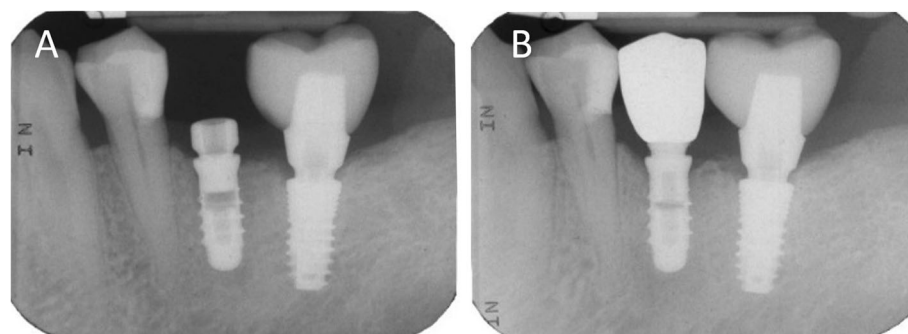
Radiographic controls before and after the prosthetic restoration. (A) Endoral periapical radiograph taken at the beginning of the restorative process, before the first intraoral scan, with the healing abutment in position. (B) Three years later, the crown is in function and seated with high precision over the abutment, with little or no gap
